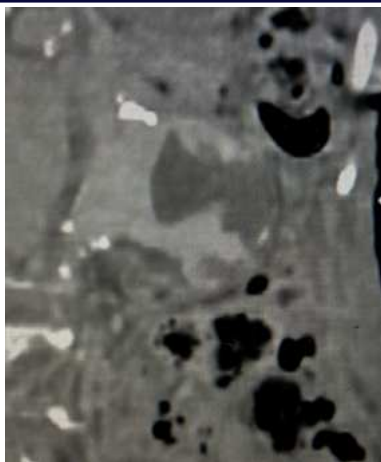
CT Abdomen – saccular aneurysm with partial thrombosis and delayed phase showing partial contrast filling
